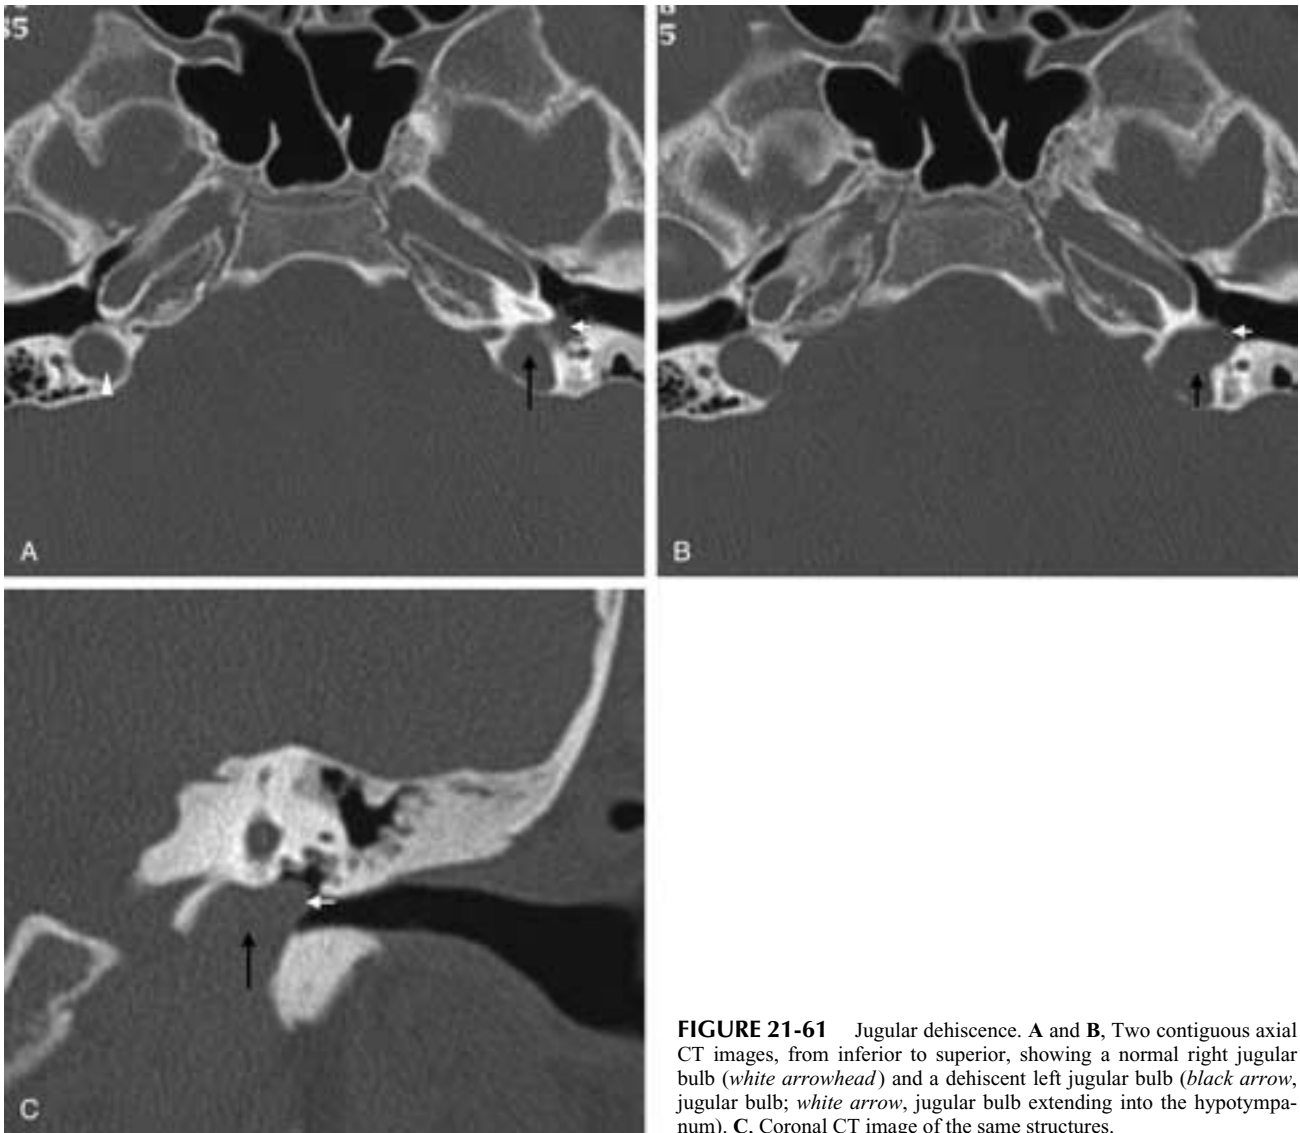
Jugular dehiscence. A and B, Two contiguous axial CT images, from inferior to superior, showing a normal right jugular bulb (*white arrowhead*) and a dehiscent left jugular bulb (*black arrow*, jugular bulb; *white arrow*, jugular bulb extending into the hypotympanum). C, Coronal CT image of the same structures.
